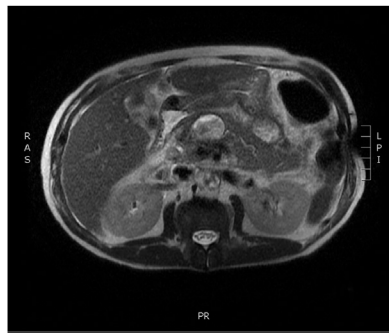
MR image shows communication between pancreatic duct and pancreatic fluid collection.
